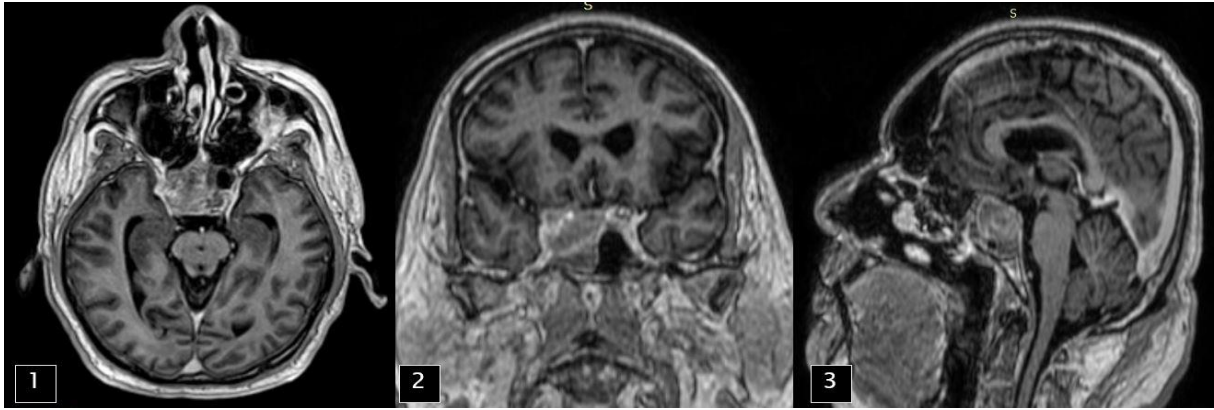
Gadolinium enhanced contrast MRI brain [1] axial [2] coronal and [3] sagittal sections of Patient 2 suggesting hypo to hyperintense non contrast enhancing lesion in sellar region with sphenoid extension
